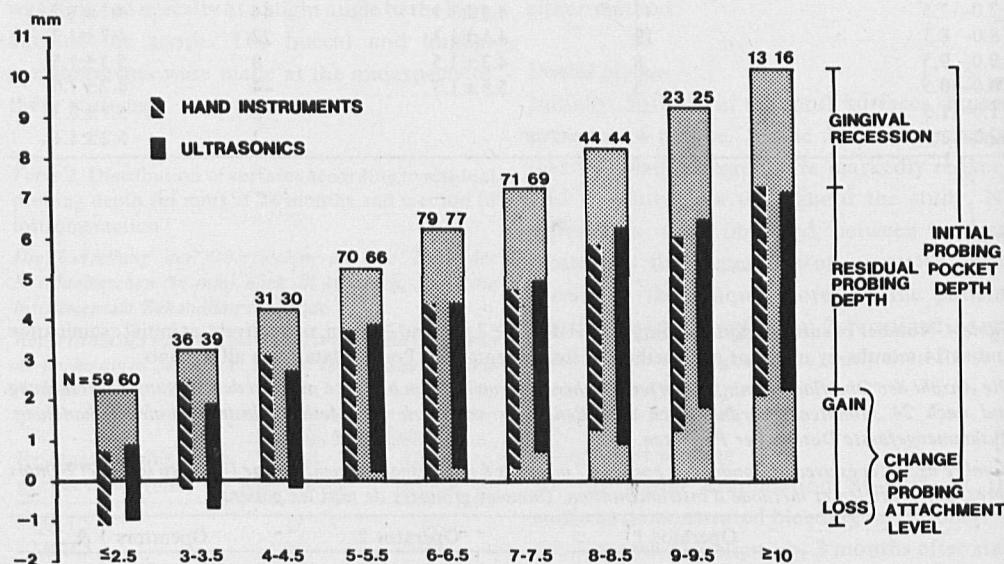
Mean amounts of gingival recession, residual probing depth and gain/loss of probing attachment level at 24 months related to initial probing pocket depth. Pooled surfaces for hand and ultrasonic instruments from all patients.
